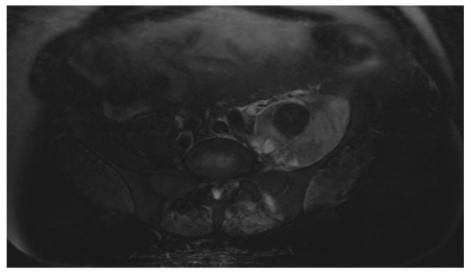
Axial MRI T2 weighted Image showing the large iliopsoas abscess.
